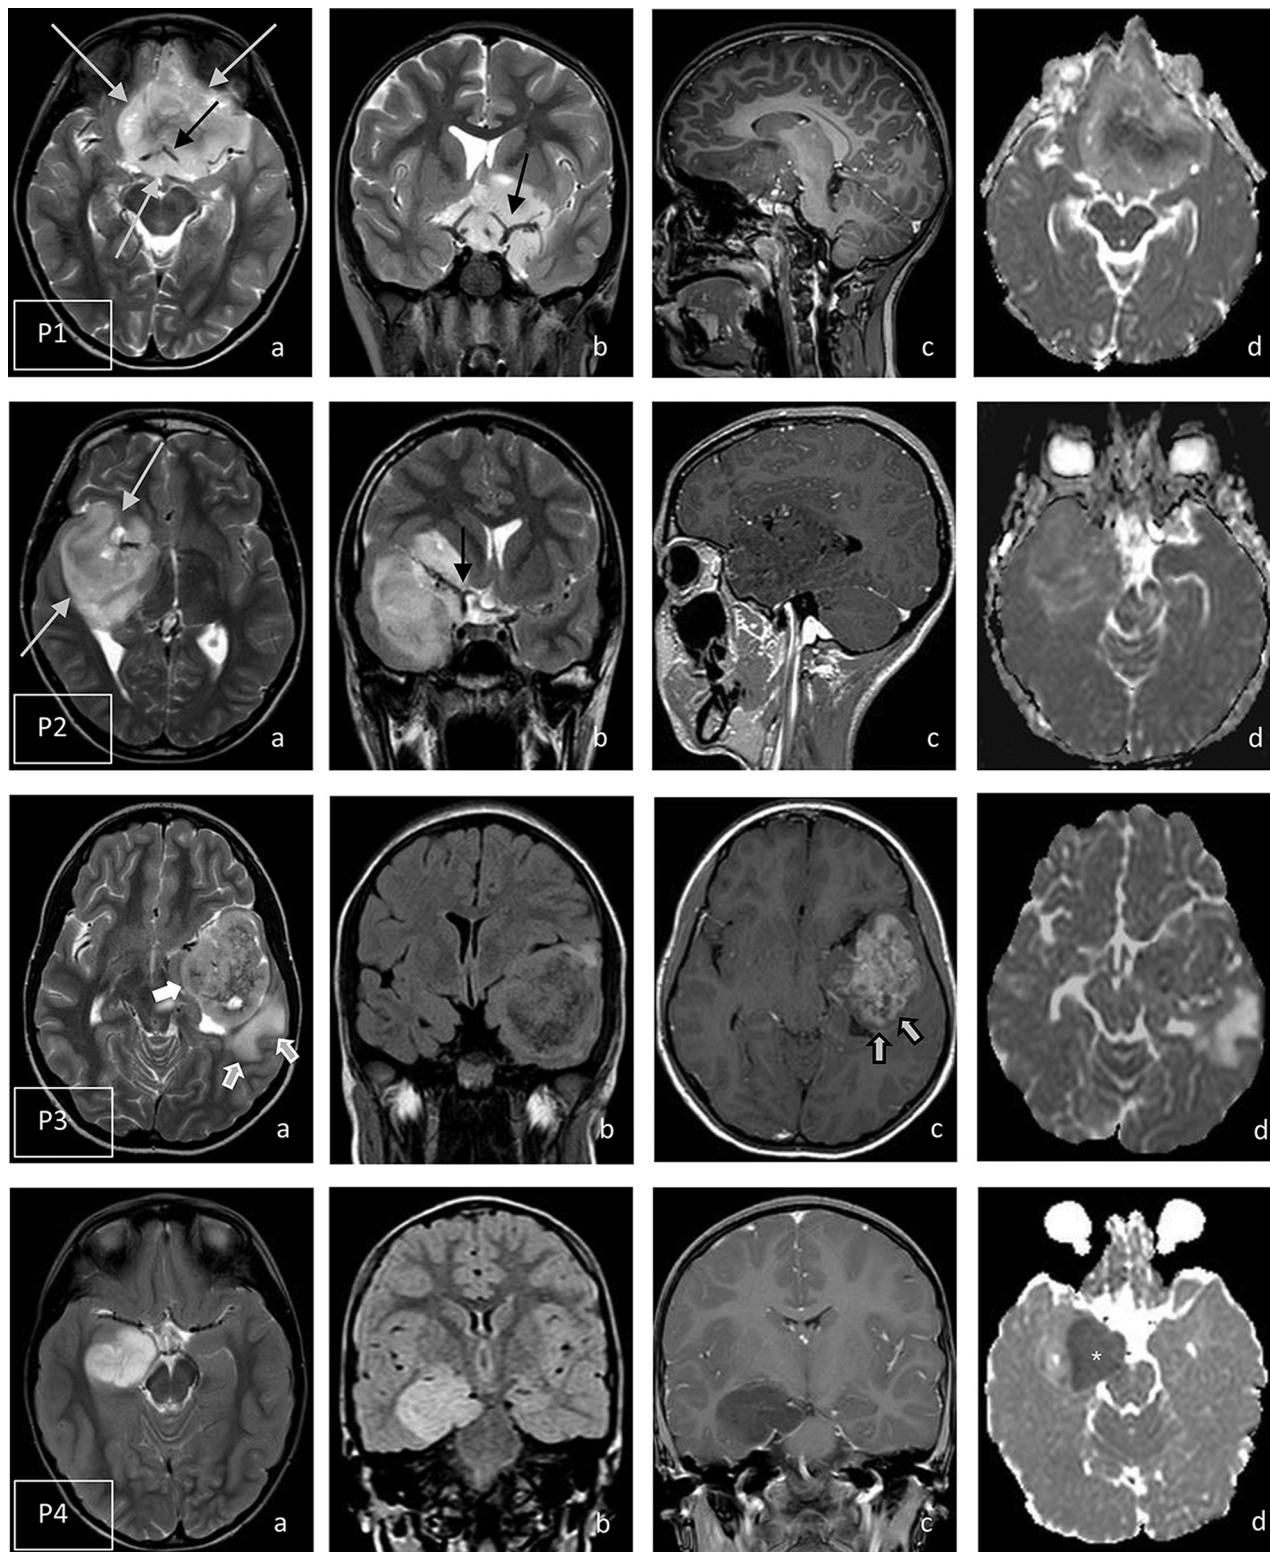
Representative MR imaging slices of all 9 patients (P1–P9). Columns: A, Axial T2WI in all MRIs; B, Coronal T2WI (P1, P2, P5) and coronal FLAIR (P3, P4, P6, P7, P8, P9); C, Contrast-enhanced T1WI, sagittal (P1, P2, P5), axial (P3, P6, P8, P9), or coronal (P4, P7); D, axial DWI/ADC in all MRIs. Long gray arrows, centrally decreased T2 signal suggestive of diffuse calcification (P1A, P2A); black arrows, tumor encompassing the circle of Willis and adjacent arteries without compression (P1AB, P2B, P5B, P9B); short gray/white arrows, marked edema (P3A); short white arrows, band-like pattern with intermediate signal on T2WI (P3A, P8A); short gray/black arrows, inhomogeneous band-like CE of the solid tumor part (P3C, P8C); white asterisk, restricted diffusion (P4D); white arrow, patchy pattern of CE affecting <25% of the tumor volume (P9C).
